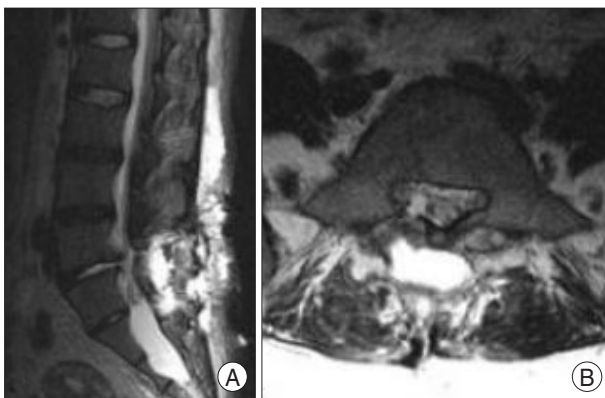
T2 weighted sagittal (A) and axial (B) magnetic resonance images taken 3 months after surgery show decrease in size of the cyst and decompressed right S1 root.
